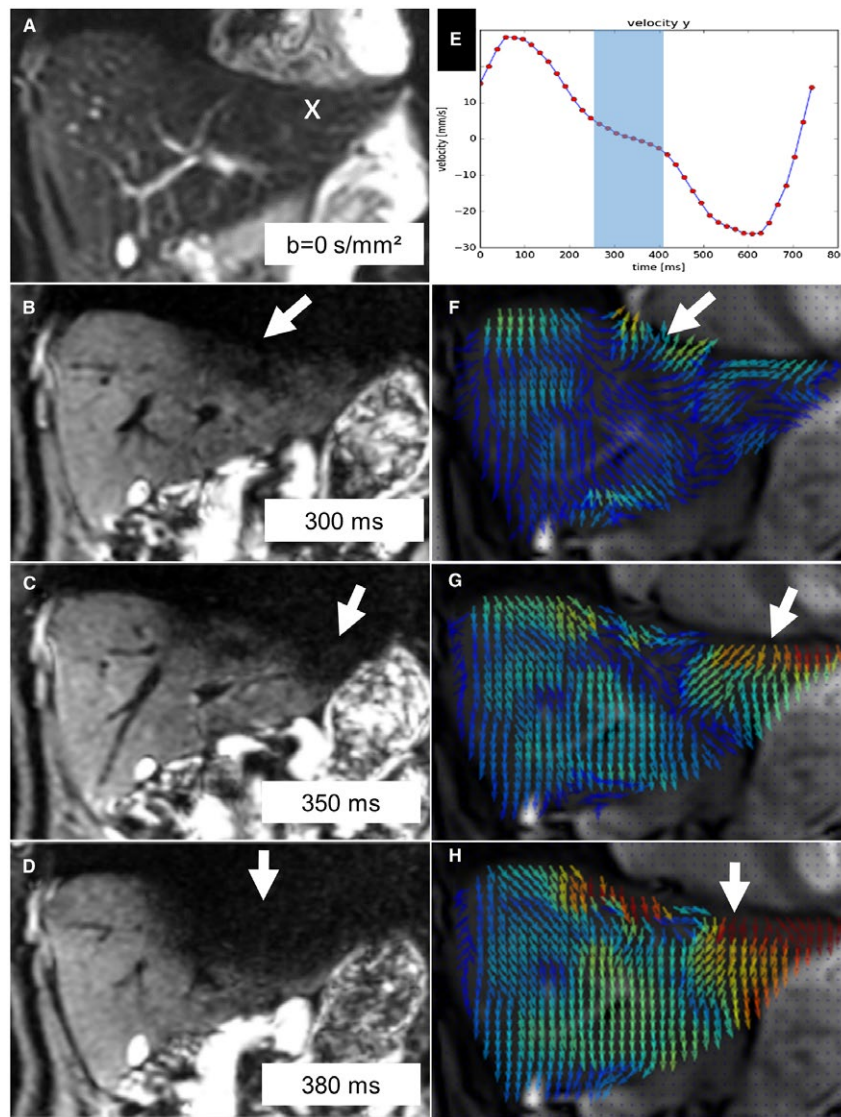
Liver coronal DWI images acquired at a fixed position with different PPU trigger delays in Vol 05. A, $b = 0$ image with a POI located in the liver left lobe beneath the heart (Couinaud segment 2), indicated by a cross. B–D, $b = 500$ s/mm² images at, respectively, 300, 350, and 380 ms. F–H, The corresponding 2D color coded velocity maps (increasing amplitude from blue to red). The amplitude of the cardiac-related artifact (white arrows) in the left liver lobe depends on the cardiac triggering time and visually correlates with the distribution and the amplitude of the velocities: signal void locations correspond to largest velocities and largest velocity gradients. E, POI velocity along the time in the FH direction. The minimum velocity time interval (blue overlay) starts at 248 ms and ends at 405 ms. For a diffusion acquisition duration of 80 ms, the acquisition must be started between 300 and 325 ms to avoid large velocity gradients that might result in strong signal losses
